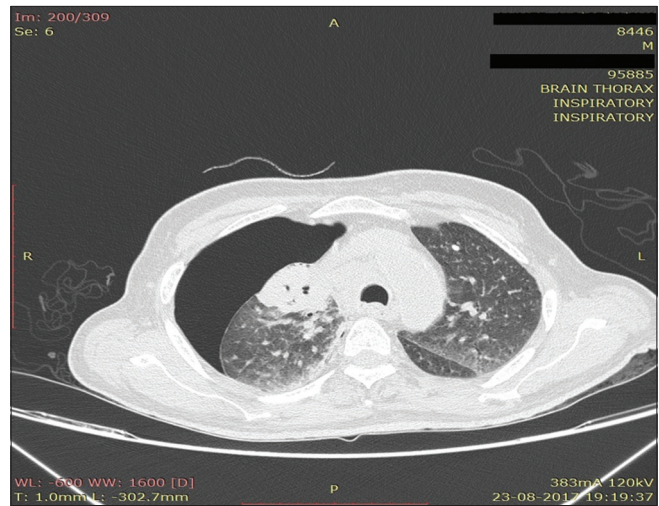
Axial image of computed tomography (CT) chest showing pneumothorax post CT-guided biopsy
